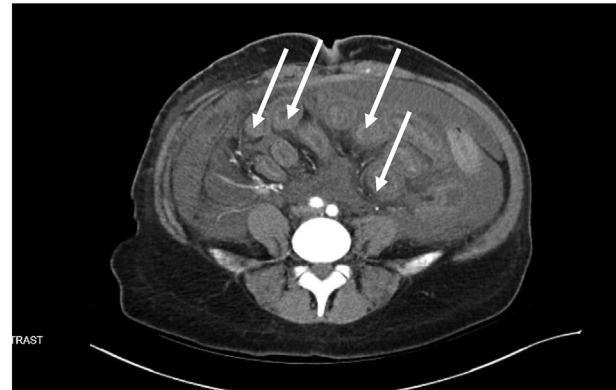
Axial view of CT abdomen with contrast showing target sign.
